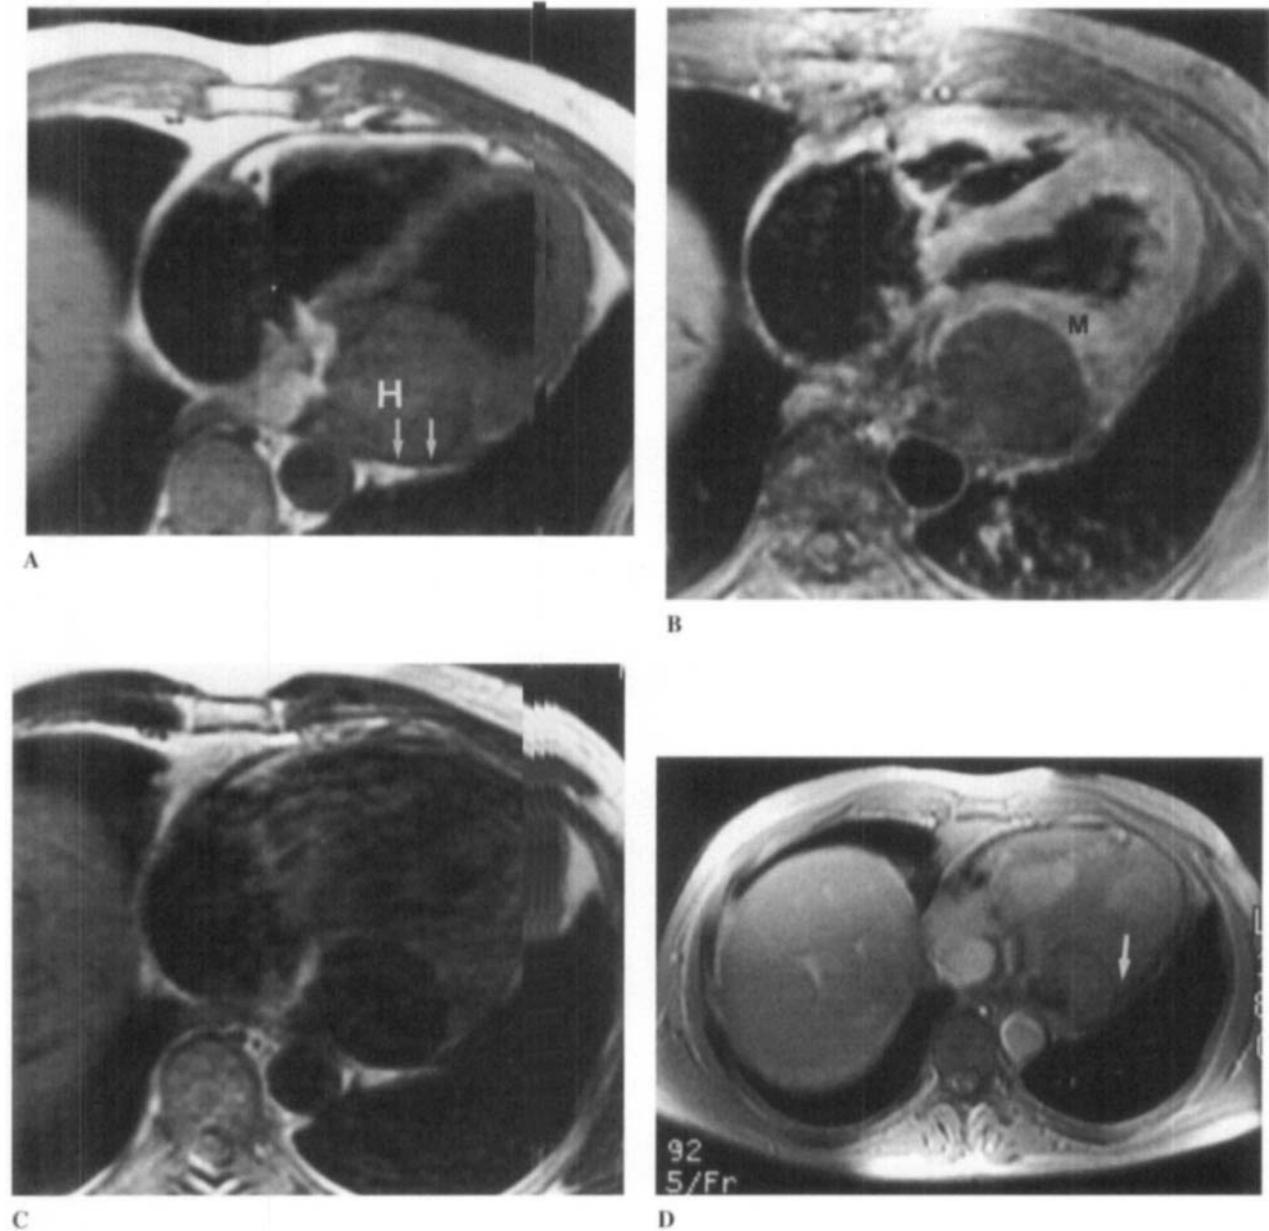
Patient 1: Axial MR images in a 39-year-old man with a history of blunt trauma to the chest. Pericardial hematoma (H) is present in the left atrioventricular groove. (A) Axial SE T1-weighted image (TR 722, TE 20) shows that the mass is of intermediate intensity and contains dark foci internally and a dark rim (arrows), likely representing central and peripheral calcification, seen at the time of surgical resection. (B) Axial SE T1-weighted image with fat suppression (TR 722, TE 20) after administration of Gd-DTPA. Note the lack of enhancement of the mass, which helps to distinguish it from the myocardium (M), which enhances normally. (C) On the axial FSE T2-weighted sequence (TR 2891, TE 90), the mass is of low signal intensity. (D) Axial cine image (TR 92, TE 5). The acute angle of the pericardial interface with the mass (arrow) is consistent with an intrapericardial location of the hematoma.
